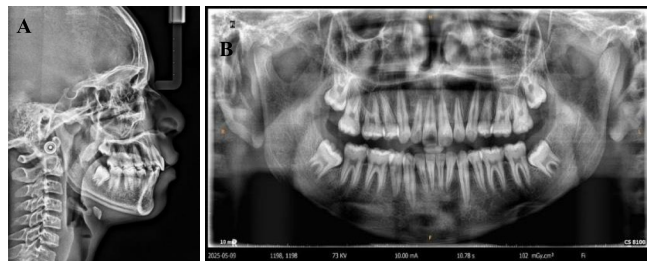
Post-treatment radiographs (A) Lateral cephalogram (B) Orthopantomogram
